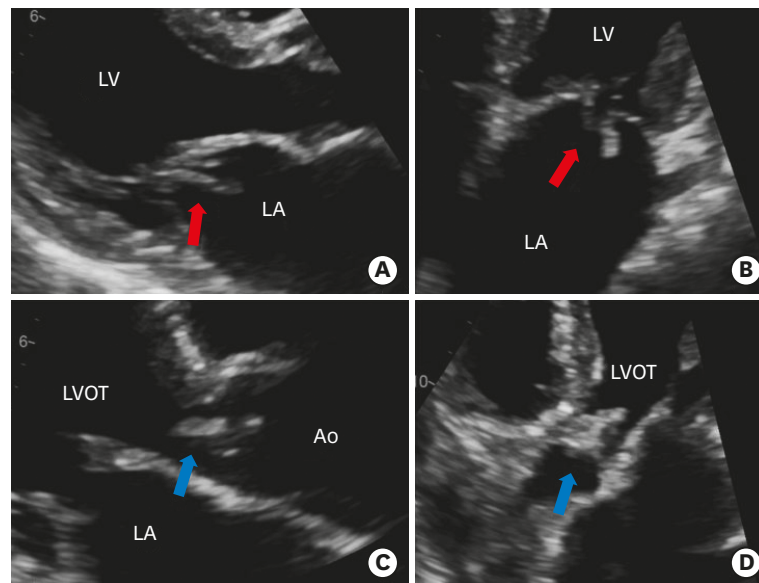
Transthoracic echocardiogram. (A) PLAX demonstrating moving masses (vegetation) on MV posterior and anterior leaflet. (B) Four chamber view of MV. (C) PLAX demonstrating moving masses (vegetation) on the AV. (D) Five chamber view of AV. Red arrow: echogenic mass at MV; Blue arrow: echogenic mass at AV. LV: left ventricle, LA: left atrium, LVOT: left ventricular outflow tract, Ao: aorta, PLAX: parasternal long-axis view, MV: mitral valve, AV: aortic valve.
